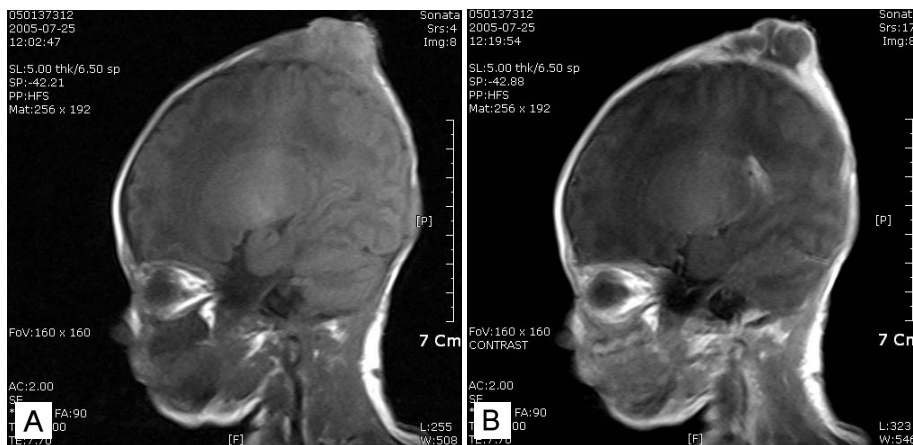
(A) Sagittal T1-weighted magnetic resonance (MR) image of the head shows swelling in the right parietal scalp. Internal signal of the swelling is heterogenous and iso to slightly high compared with gray matter. (B) Sagittal T2-weighted magnetic resonance (MR) image shows this lesion is abscess with high internal signal intensity. After contrast media injection, peripheral enhancement is noted.
